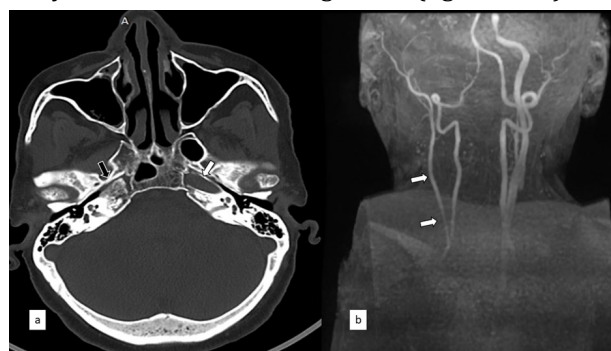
(a) Axial reformatted CT skull base (bone window) shows the absence of the right carotid canal (black arrow) and a normally developed left carotid canal (white arrow). (b) Time of flight (TOF) MRA with coronal maximum intensity projection (MIP) of the neck vessels shows a complete absence of the right ICA with small-caliber right common carotid artery continuing as external carotid artery (white arrows).
